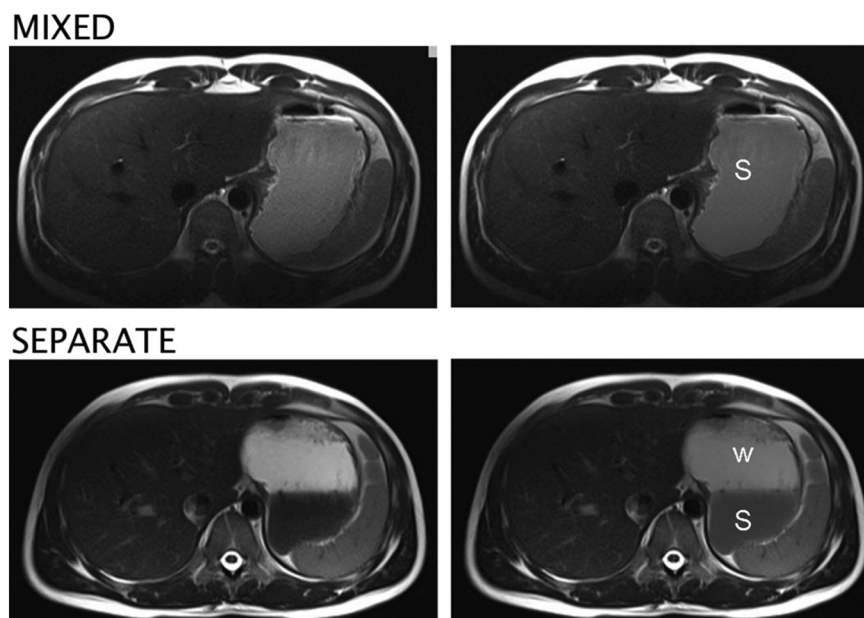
Example gastric MRI images. Shown are transverse slices at the height of the liver, directly after ingestion. Left: original images. Right: the same slices as shown on the left but with the gastric content highlighted manually based on signal strength as indicated by colorization. S: shake fraction. W: water fraction. Water yields high signal in a T_2 -weighted scan, and therefore appears bright. In the MIXED condition a uniform coloration of the gastric content can be observed. In the SEPARATE condition, owing to the watery content, a whiter layer can be observed on top of the shake layer. In Supplemental Fig. 2 an in vitro example of the SEPARATE condition is shown.
